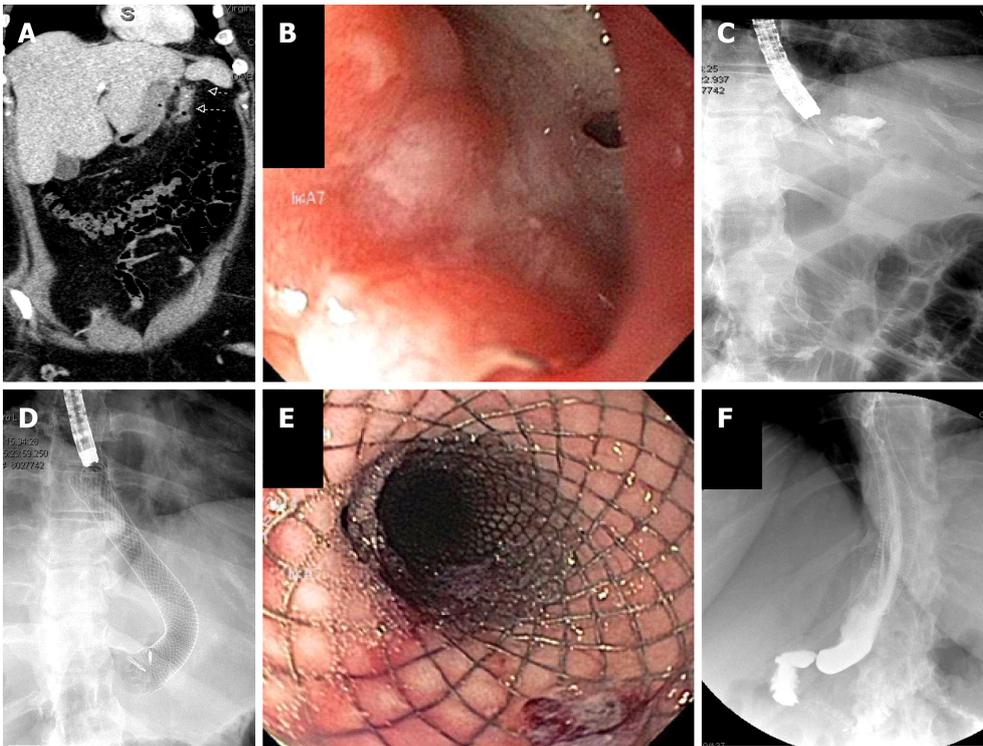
Sleeve leak treated with covered esophageal stent. Computed tomography imaging demonstrating sleeve leak; B: Endoscopic appearance of leak site; C: Contrast injection to confirm leak site; D: Placement of covered self-expandable metal stents; E: Endoscopic appearance of stent; F: Subsequent upper gastrointestinal series showing no residual leak after stent placement.
